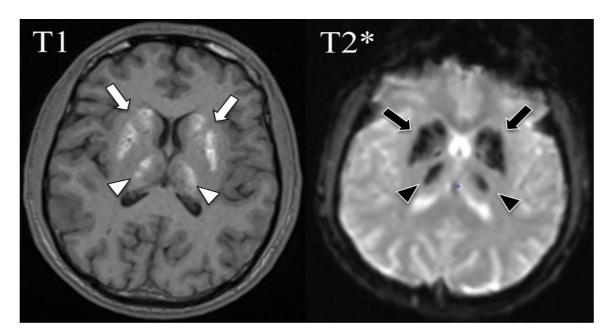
Axial brain MR views showing a high intensity signal of the thalami (white arrow heads), lentiform and caudate nuclei (white arrow) on T1-weighted images, and a very low intensity signal in T2*-weighted images (black arrows and arrow heads), highly suggestive of calcifications.
